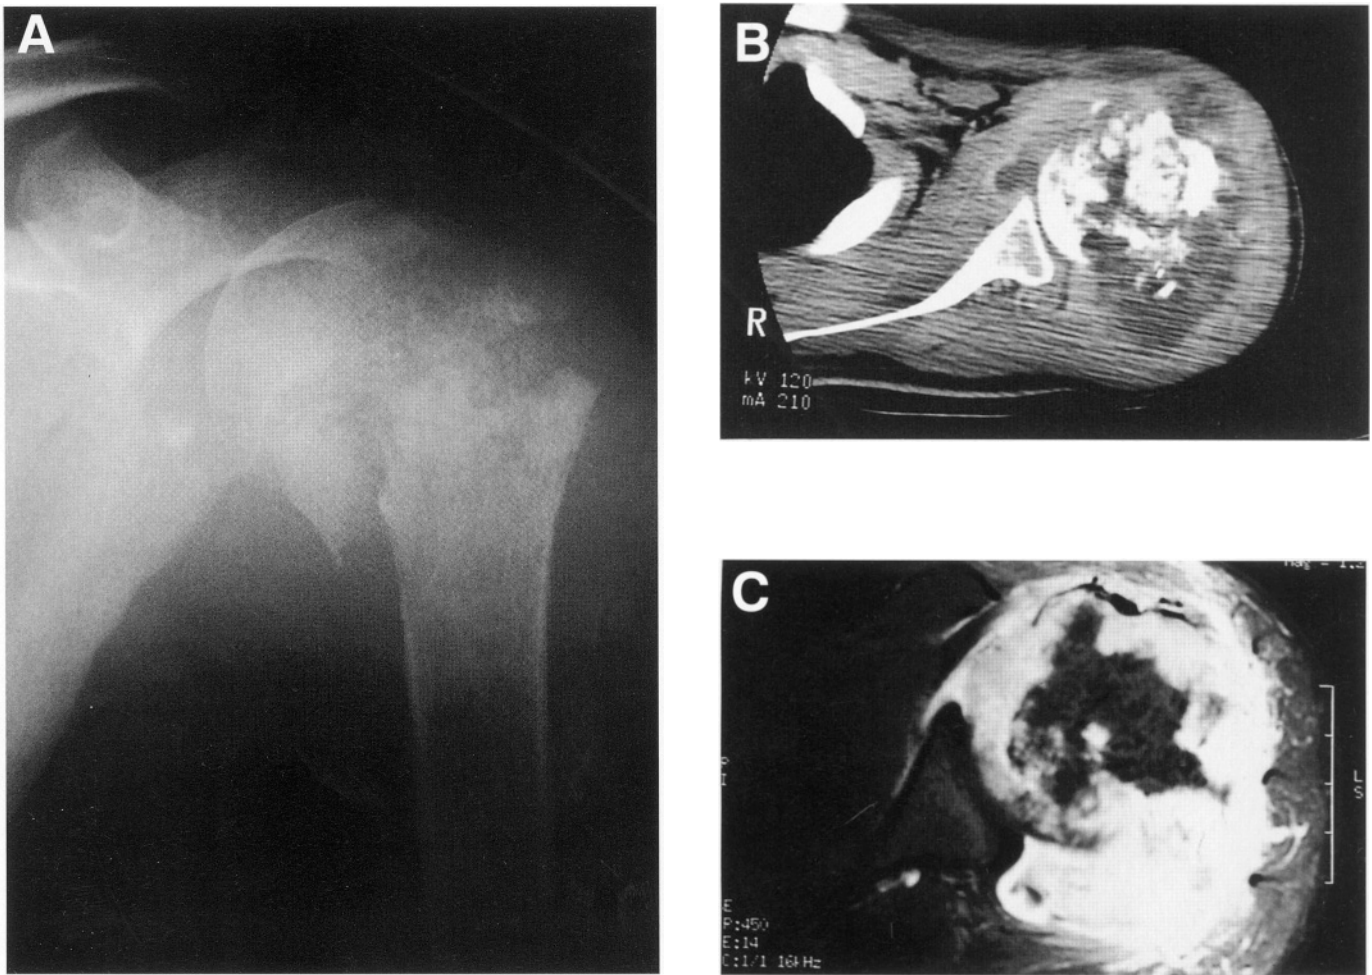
(A) Plain radiograph of an osteosarcoma of the proximal humerus with a pathologic fracture. In general, osteolytic osteosarcoma is the specific type of osteosarcoma that may develop a pathologic fracture. (B) CT scan showing a large soft-tissue component at the fracture site. Note the extension around the glenohumeral joint. Tumors of the proximal humerus may often involve the glenoid and are therefore treated by extra-articular resection (Type V). (C) MRI of the same patient showing extensive tumor involvement of the glenohumeral joint and pericapsular mechanisms.
